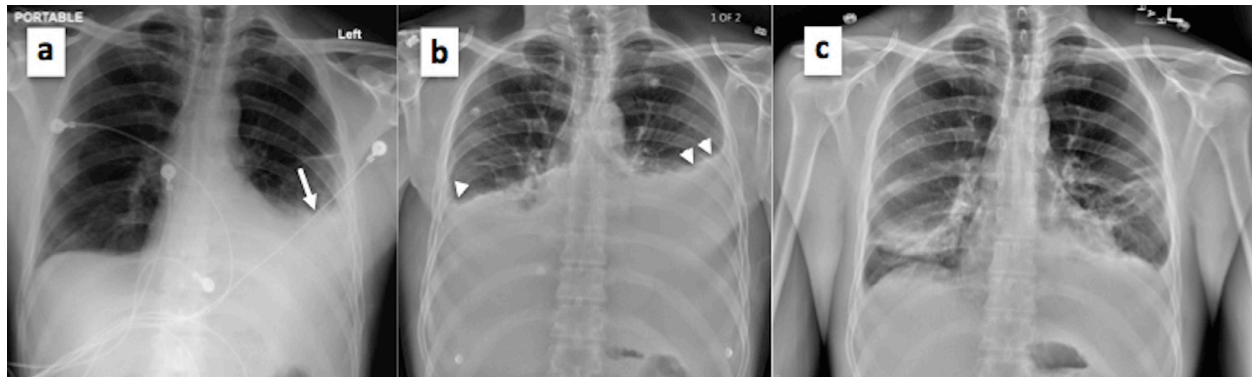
(a-c). Plain radiograph of the chest showing (a) obliteration of the left costophrenic angle on initial presentation (white arrow); (b) reaccumulation of chylothorax with bilateral obliteration of costophrenic angles on second patient admission (white arrow heads); and (c) resolution of chylothorax effusion prior to final patient discharge.
